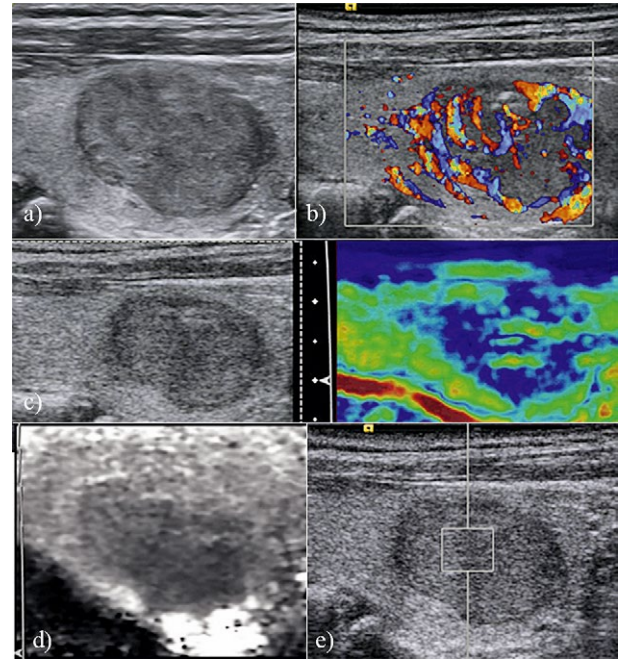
Ultrasound elastography in medullary thyroid carcinoma in a 72-year-old woman. A 20 mm thyroid nodule that appears as hypo-echogenicity, well defined margin, presence of halo sign, and rich intranodular and peripheral flow was found in left lobe of the thyroid at conventional US (a,b). The EI score 3 (c, the nodule is displayed predominantly in blue with few green areas/spots), VTI grade IV (d, most lesion is displayed in black with a small amount of white) and SWV of 2.71 m/s (e) on VTQ are assigned at elastography.
